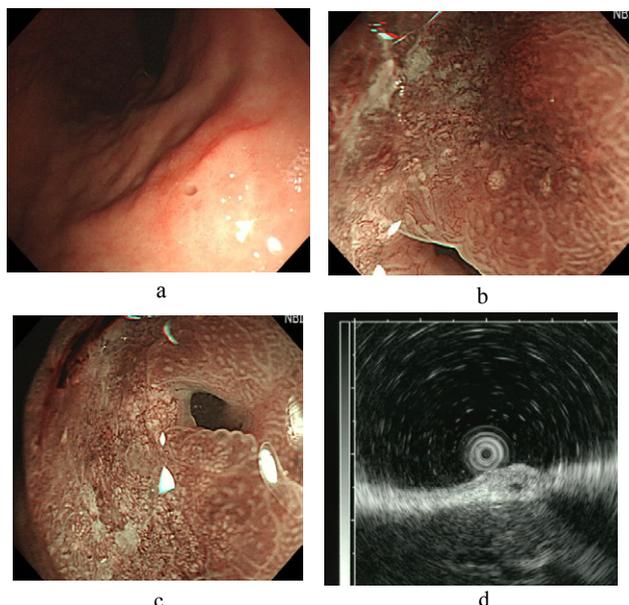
a. Gastroendoscopy revealed a small orifice near the anal side of the depressed lesion, which was considered to be gastric gland heterotopias. b and c. Narrow-band imaging endoscopy revealing irregular vascular patterns in the surface structures of the type 0-IIc lesion; this is consistent with the findings of gastric cancer. d. Endoscopic ultrasonography revealed that an anechoic lesion in the third layer was adjacent to a depressed lesion, suggesting that the depressed lesion had invaded the submucosal layer.
